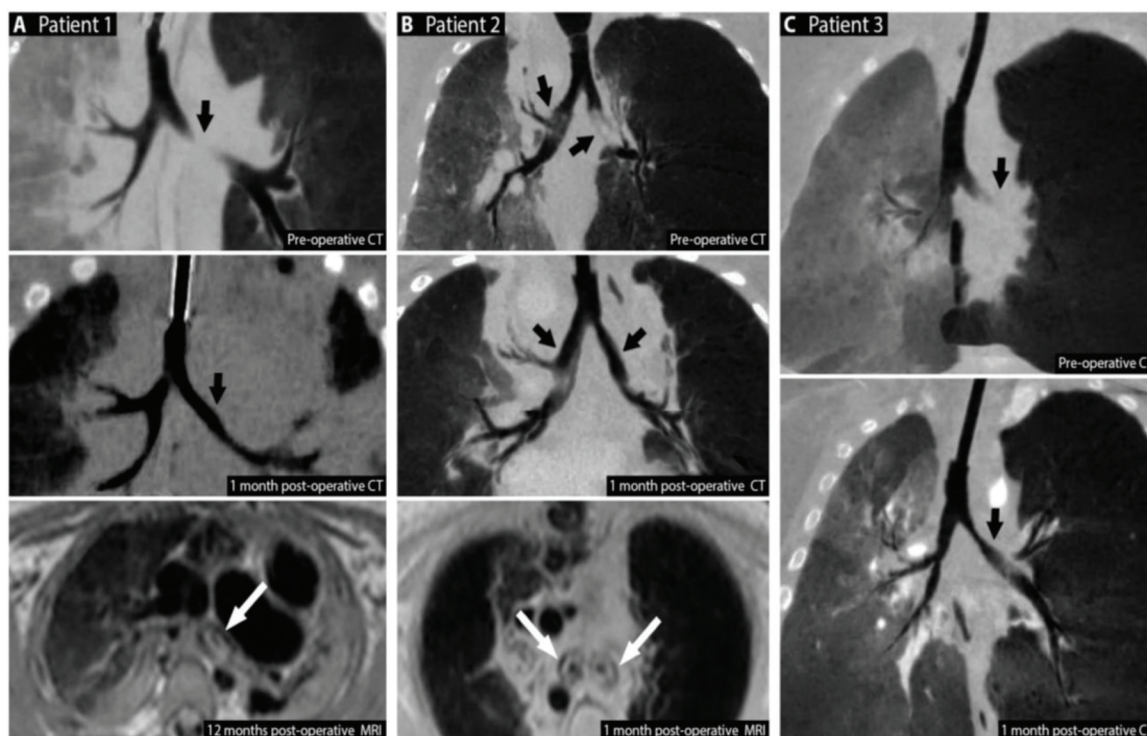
Pre- and postoperative imaging of patients. Black arrows in all figures denote the location of the malic segment of the airway. White arrows indicate the location/presence of the tracheobronchial splint. Asterisk denotes focal degradation of the splint. All CT images are coronal minimum intensity projection (MinIP) reformatted images of the lung and airway on expiration. All MRI images are axial proton density turbospin echo MRI images of the chest. (A) Preoperative (top) and 1-month postoperative (upper middle) CT images of patient 1. Postoperative MRI (lower middle) demonstrated the presence of the splint around the left bronchus in patient 1 at 12 months, and focal fragmentation of the splint due to degradation at 38 months (bottom). (B) Preoperative (top) and 1-month postoperative (upper middle) CT images of patient 2. Postoperative MRI (lower middle) demonstrated the presence of splints around the left and right bronchi in patient 2 at 1 month. Note that the patient had bilateral mainstem bronchomalacia and received a tracheobronchial splint on both the left and right mainstem bronchi. (C) Preoperative (top) and 1-month postoperative (bottom) CT images of patient 3. Reproduced from ref. 53 with permission from [Science], copyright [2015].
